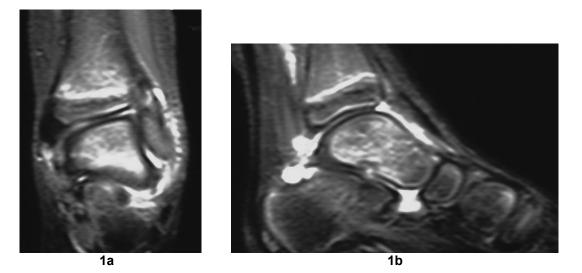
T2-weighted fat-suppressed images of a 6-year-old girl revealed bone bruising of the talus, evidence of soft tissue injury on the lateral side of the ankle joint (a) and pronounced fluid signal around the talus (b)
